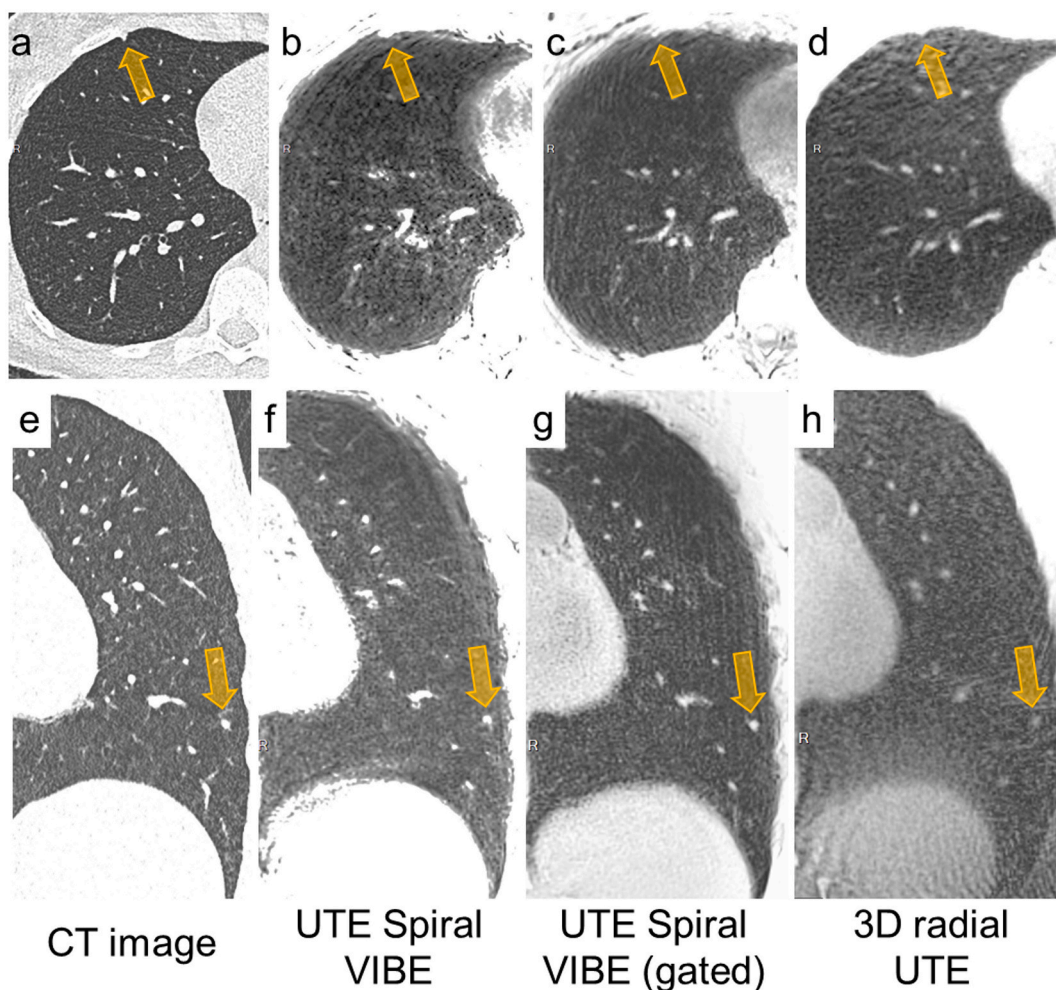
Nodules observed in two healthy volunteers with CT and MR sequences. a-d. Axial view acquired with CT a., UTE Spiral VIBE non-gated b., gated c. and 3D radial UTE d. sequences. The nodule (orange arrows) was only seen and reported as such with CT. e-h. Coronal view acquired with CT e., UTE Spiral VIBE non-gated f., gated g. and 3D radial UTE h. sequences. Although visible with all MR sequences, the nodule (orange arrows) was much less visible on 3D radial UTE sequences due to the low contrast with the neighboring parenchyma and considered as non-relevant by one reader.
